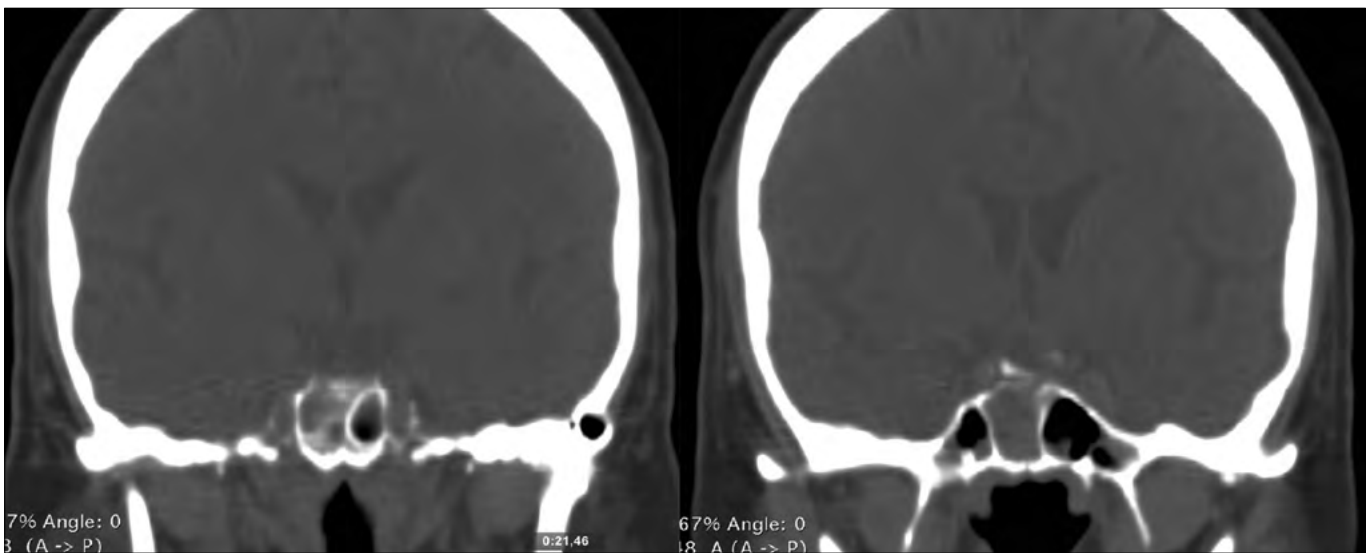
Brain CT-scan 6 hours after surgery showing complete removal of the tumour.
